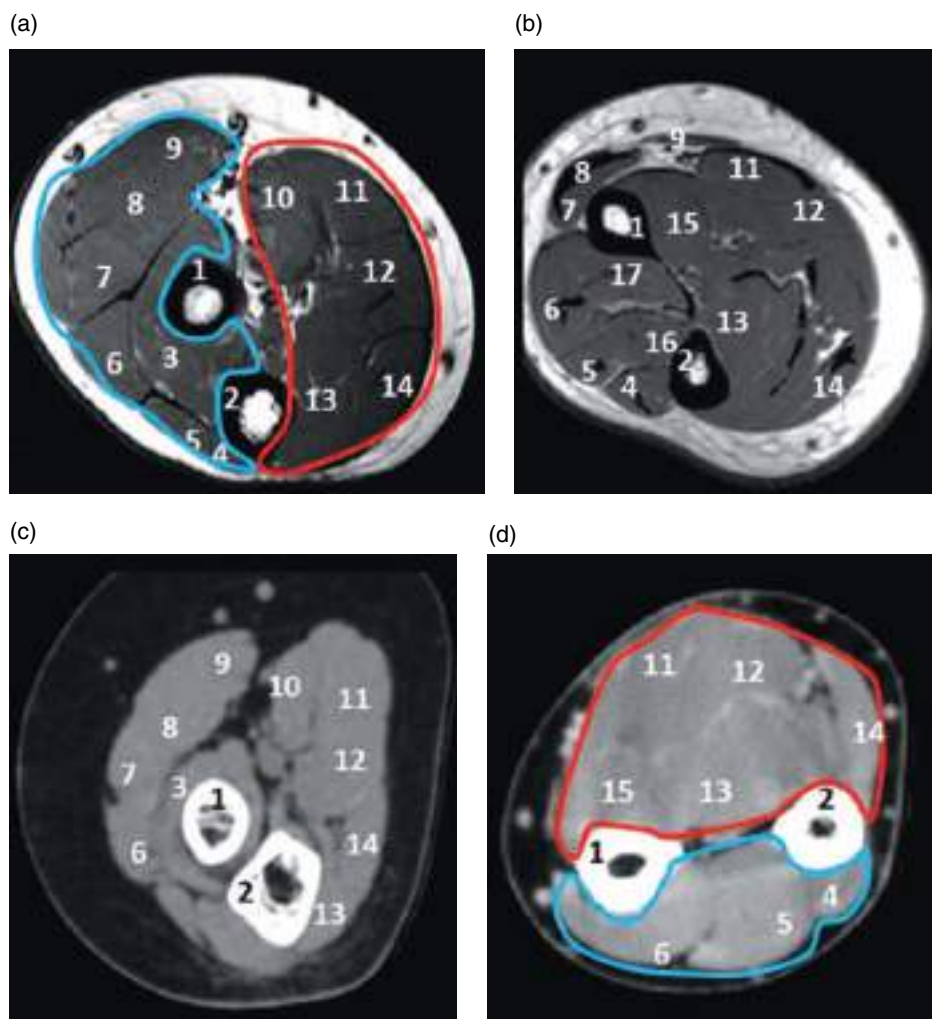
Forearm compartments. Axial T1 MR sequence of the proximal (a) and middle (b) forearms. CT scan of the proximal (c) and middle (d) forearms. 1, radius; 2, ulna; 3, supinator; 4, extensor carpi ulnaris; 5, extensor digiti minimi; 6, extensor digitorum; 7, extensor carpi radialis brevis; 8, extensor carpi radialis longus; 9, brachioradialis; 10, pronator teres; 11, flexor carpi radialis; 12, flexor digitorum superficialis; 13, flexor digitorum profundus; 14, flexor carpi radialis; 15, flexor pollicis longus; 16, extensor pollicis longus; 17, abductor pollicis longus and extensor pollicis brevis; red, anterior compartment; blue, posterior compartment.
